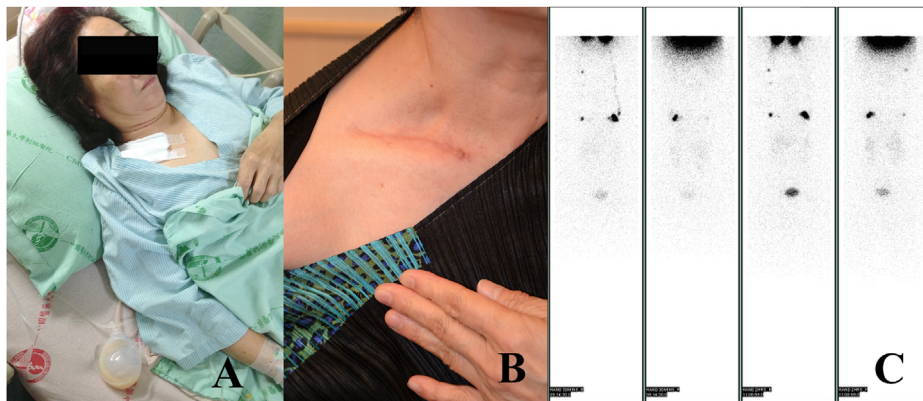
A 51-year-old female with right lower extremity lymphedema after total hysterectomy, inguinal lymph node dissections, and postoperative radiotherapy. She underwent a vascularized supraclavicular lymph node transfer to the ankle. However, the 1st day after SC-VLN transfer patient develop lymph leakage from its donor site (A). This patient was managed conservative using compression and suction drain for 14 days. At 24-month follow-up, the patient did not have any symptom of donor site and right upper limb lymphedema clinically (B) and by lymphoscintigraphy (C) post SC-VLN transfer.
